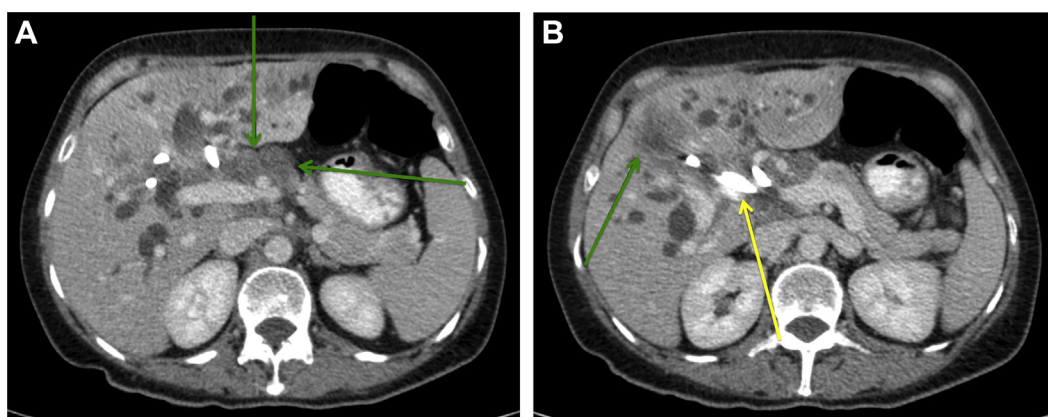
CT axial images of porta hepatis tumor (green arrow) (A); liver metastasis (green arrow) and presence of stents in the common bile duct (yellow arrow) (B).
